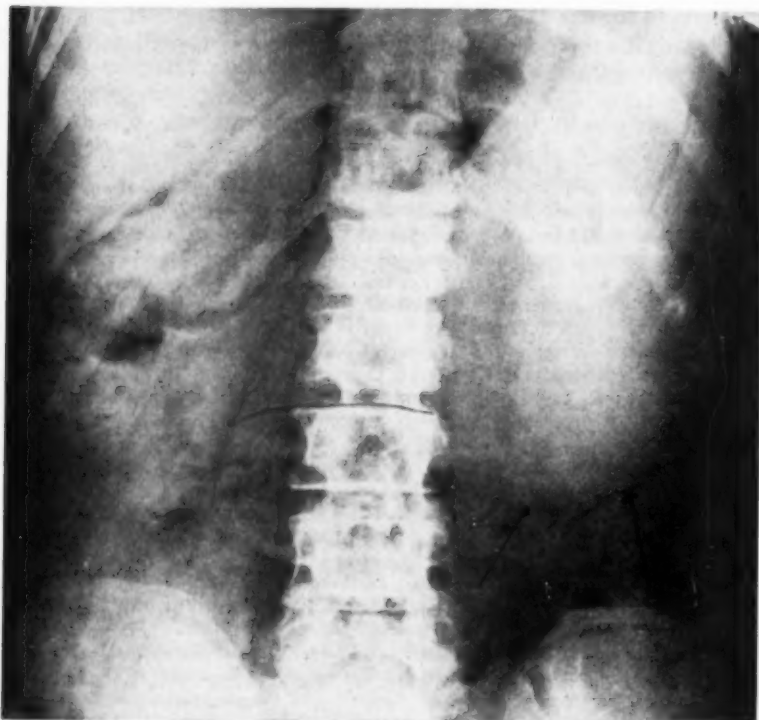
Case 1. Flat plate of abdomen showing large spleen. Splenomegaly may often be detected by radiograph.
